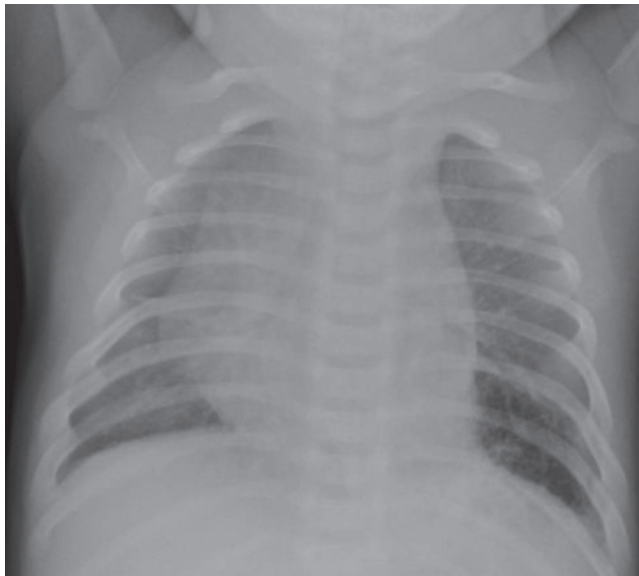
Frontal chest radiograph shows a focal opacity located in the medial left lower lobe, retrocardiac region.
